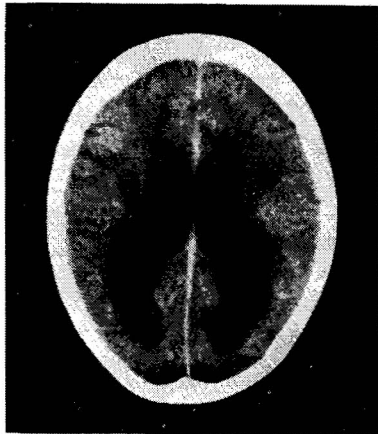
CT scan showing hydrocephalus following tuberculous meningitis
